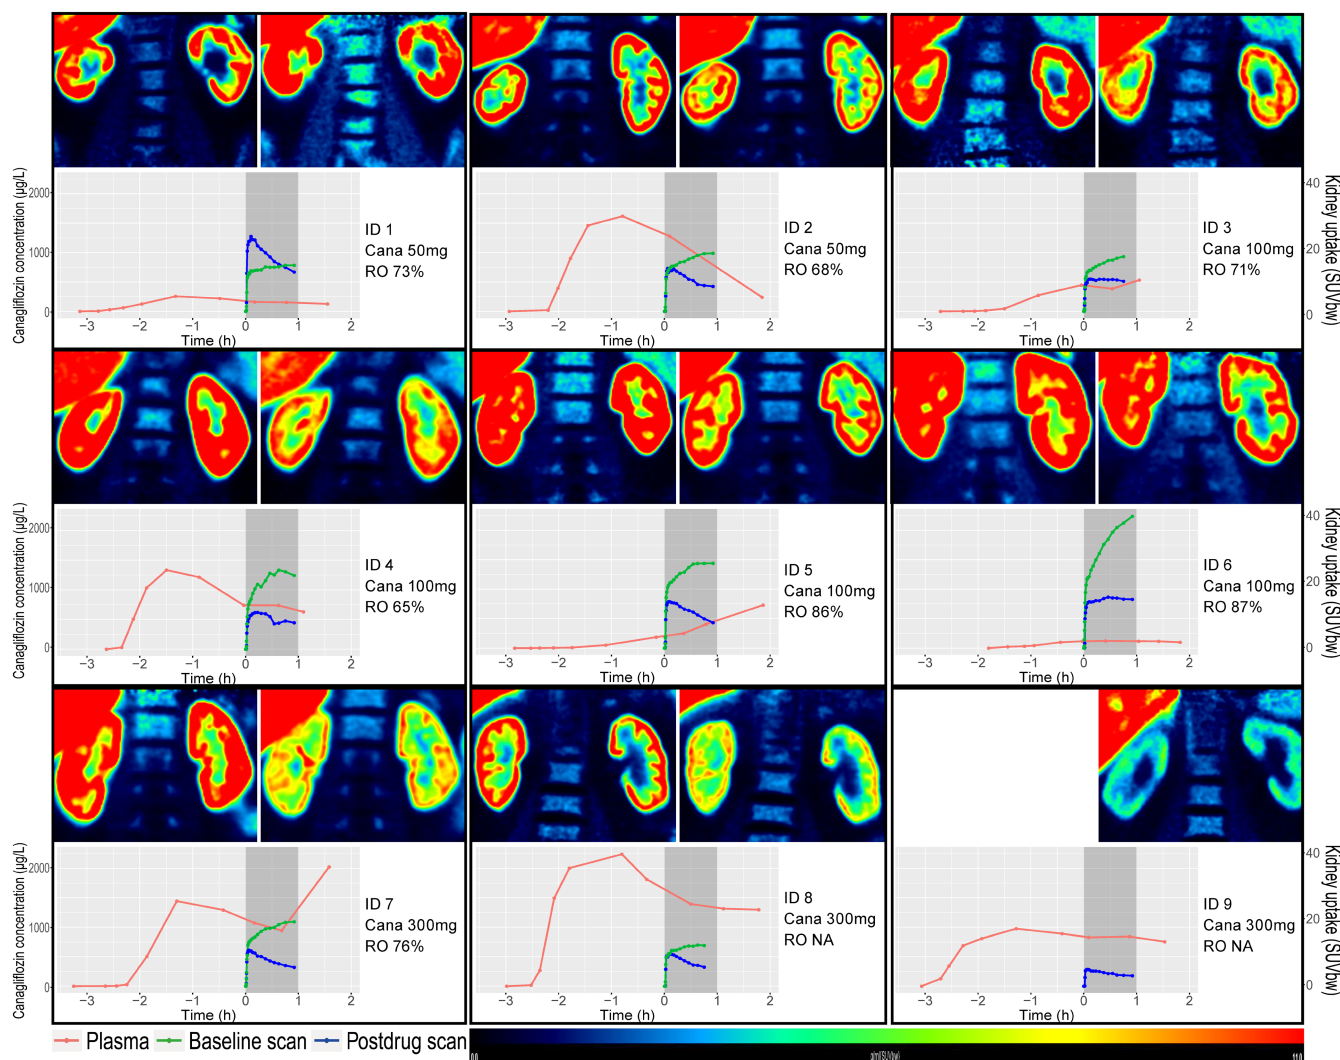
Combined PET and pharmacokinetic data per participant (ID). Top row: PET images of [^{18}F]canagliflozin uptake in part of the liver and both kidneys ~25 minutes after tracer administration ($t=0$ hours) for the baseline (left) and post-drug scan (right). Bottom row: Plasma canagliflozin concentration (red, left y-axis) and individual time activity curves of [^{18}F]canagliflozin uptake (right y-axis) in both kidneys from the baseline (green) and post-drug (blue) PET scan. Gray bars: time frames of PET data acquisition used for kinetic analyses. PET images are scaled 0–11 SUVbw. NA, not applicable; PET, positron emission tomography; RO, apparent receptor occupancy; SUVbw, standardized uptake value, normalized to body weight, calculated as tissue radioactivity [KBq/g]/(injected dose [MBq]·body weight [kg]).
